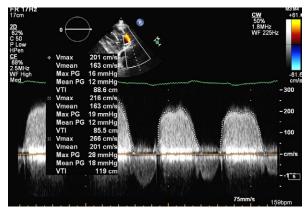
Transthoracic echocardiogram with color-flow Doppler shows severe tricuspid bioprosthesis stenosis (mean diastolic Doppler gradient, 15 mmHg) before valvuloplasty.
